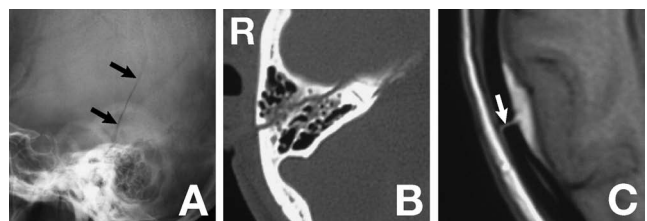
(A) Radiograph showing a fracture line (arrows) in the temporal bone. (B) Computed tomography scan demonstrating a longitudinal fracture in the petrosal bone and a hematoma in the mastoid air cells. (C) Posttreatment T₂-weighted magnetic resonance image revealing the epidural hematoma, and the fracture line (arrow) in the temporal bone adjacent to the hematoma.
